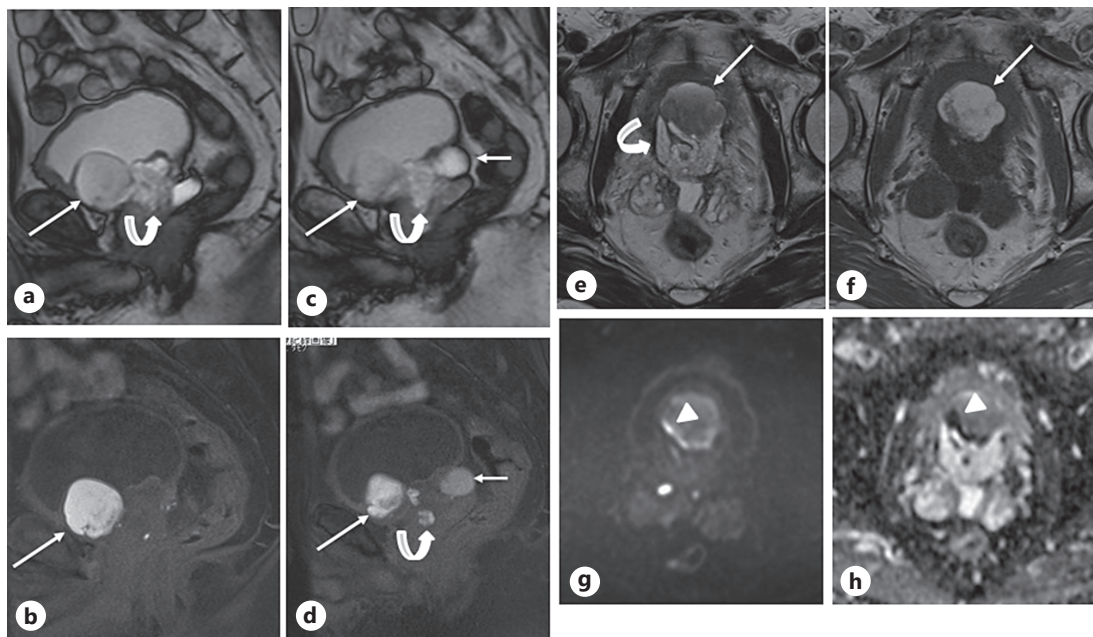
Pelvic MRI finding. MRI demonstrated a hemorrhagic, 30 × 40 × 33 mm in size, multilocular cyst (long arrow) projecting into the bladder side from the prostatic inner gland, showing high signal intensity with shading on (a, c) T2-weighted imaging and high signal intensity on (b, d) the fat-suppression T1-weighted image. Likewise, MRI demonstrated a hemorrhagic, 22 × 22 × 20 mm in size, multilocular cyst (short arrow) between the prostate and the right seminal vesicle, showing high signal intensity on (c) T2-weighted imaging and high signal intensity on (d) the fat-suppression T1-weighted image. The prostate inner gland (curved arrow) showed high signal intensity on (a, c, e) the T2-weighted image and included tiny hyperintense spots on (b, d) the fat-suppression T1-weighted image. In the part of the border of the hemorrhagic, multilocular cyst projecting into the bladder side from the prostatic inner gland, a solid portion showing slight low intensity on (f) T1-weighted imaging and markedly restricted diffusion (high signal intensity on g diffusion coefficient imaging [DWI] and low signal intensity on h ADC) (triangle) was observed, suggesting prostate cancer. ADC, apparent diffusion coefficient.
